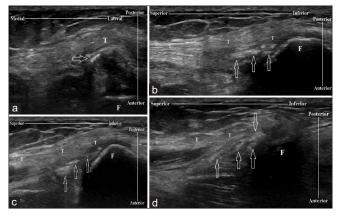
Sonographic images of the posterior lateral right knee. (a) Short-axis image and (b) and (c) long-axis images demonstrate multiple echogenic calcific foci (open arrows), within the heterogenous biceps femoris tendon (T) insertion at the fibular head (F). (d) Long-axis image obtained just posterior to the biceps femoris tendon (T) shows some amorphous echogenicity (open arrows) extending into the soft tissues immediately adjacent to the tendon
